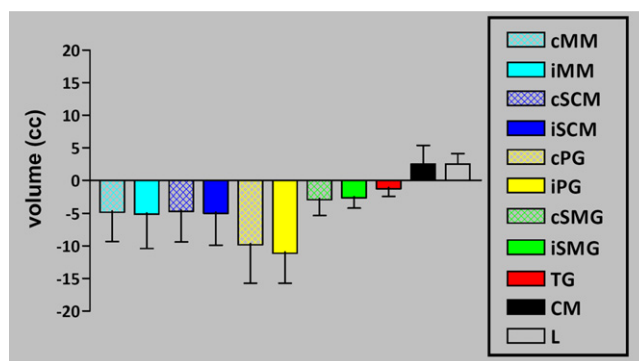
Absolute volume reduction from planning computed tomography to week 7 by organs at risk. Abbreviations: OAR = organs at risk; PG = parotid gland; SMG = submandibular gland; CM = constrictor muscles; MM = masticatory muscles; SCM = sternocleidomastoid muscle; L = larynx; TG = thyroid gland; i = ipsilateral; c = contralateral.
